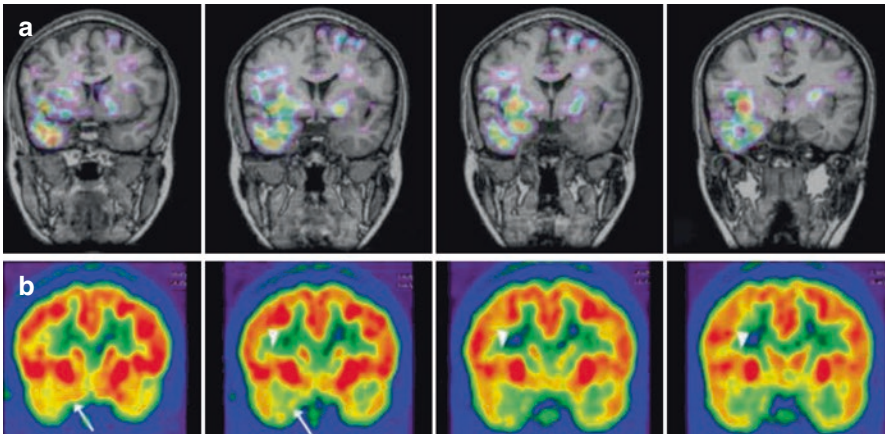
SISCOM and FDG-PET. SISCOM images show the hyperperfusion in the right anterior mesial temporal regions, amygdala, hippocampal head, and insula (a). FDG-PET demonstrates interictal hypometabolism in the right amygdala (*arrow*), hippocampal head, and insula (*arrow heads*) (b)
